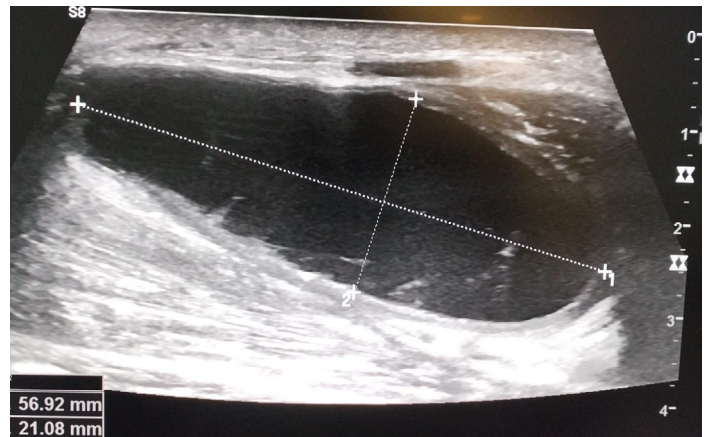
Ultrasound examination showing pus collection in the muscle.
